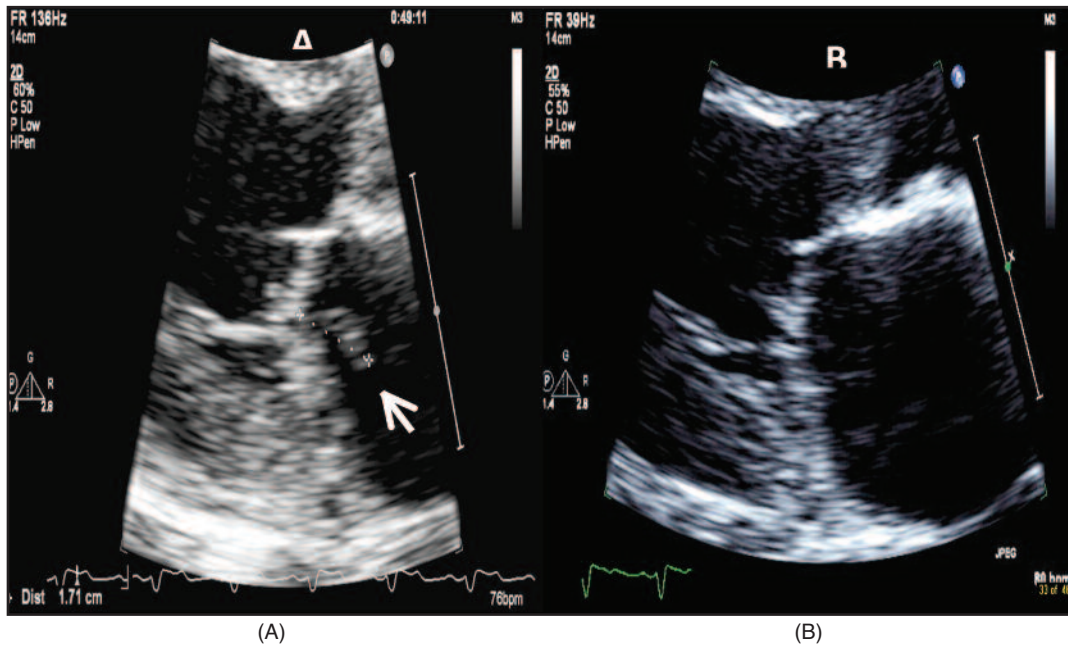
Transthoracic echocardiogram image showing 1.2cm mobile vegetation sitting on the posterior aspect of the Mitral valve leaflet (A) and complete resolution of the mitral valve vegetation post-treatment (B).
